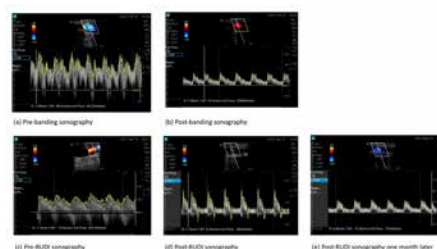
The serial sonography presented the brachial artery inflow before and after intervention. RUDI, revision using distal inflow.
